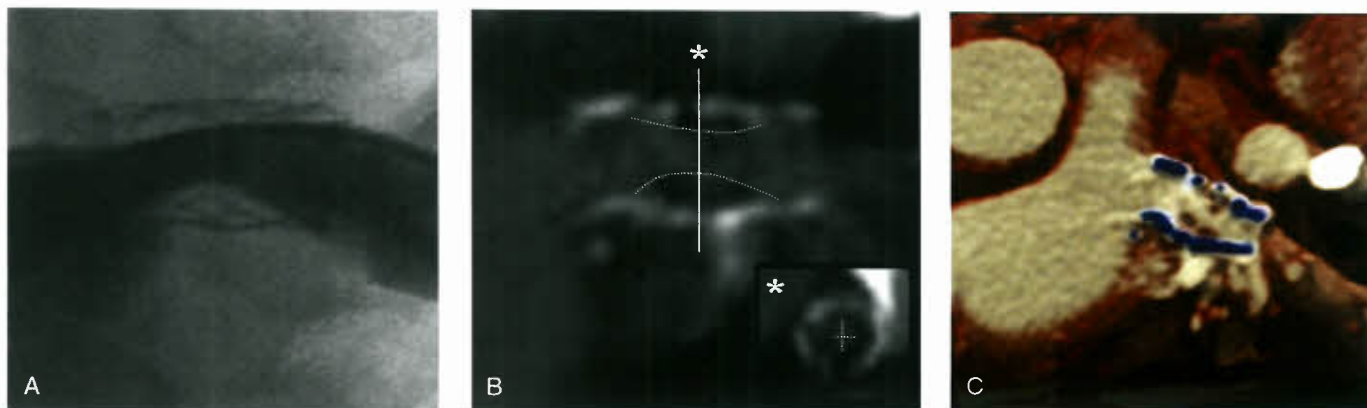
A 4-year-old child with an LPA stent. A: Digital angiogram shows narrowing or a moderate in stent restenosis which is greatest at its mid-portion. B: CTA 2-D multiplanar reconstruction of stent. C: Three-dimensional volume rendering shows stent (blue dashes).
